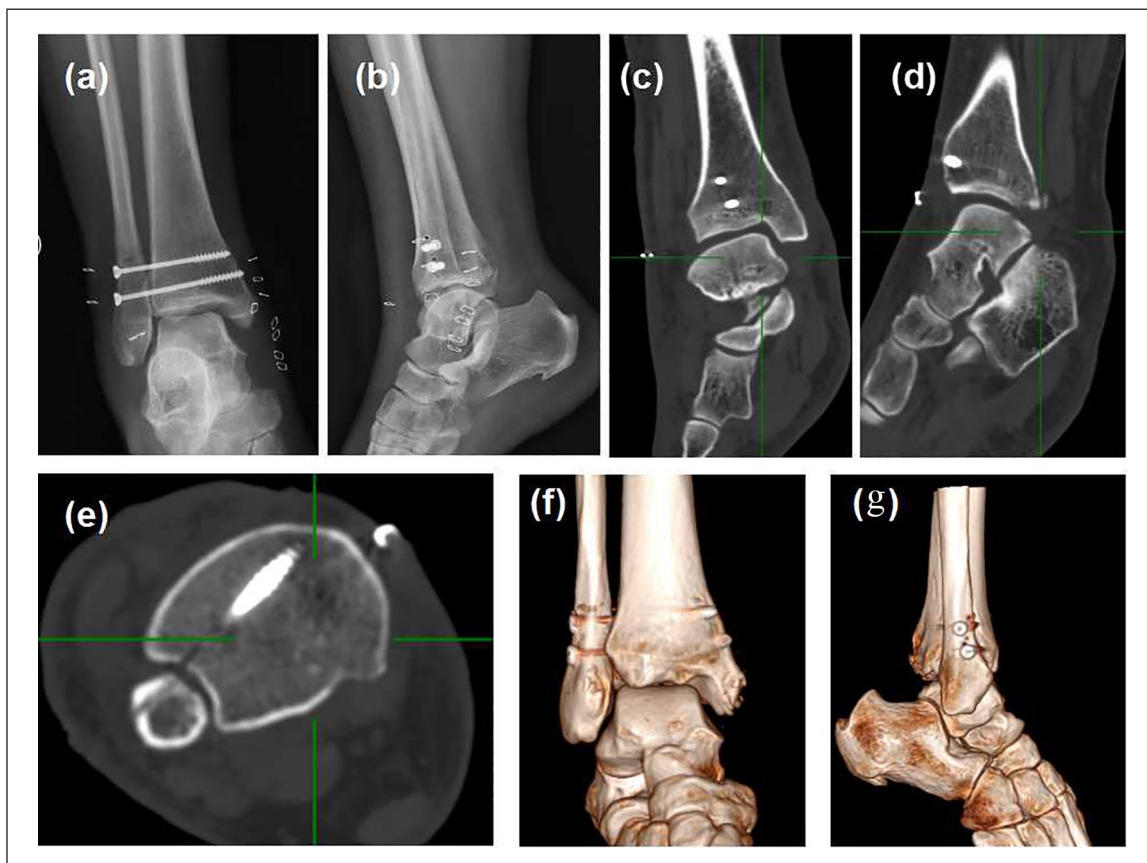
Postoperative images showing the satisfactory position of the injured ankle. (a, b) Postoperative radiographs showing full reduction of the distal dislocated fibula and near anatomical joint space of the ankle. (c, d) Satisfactory tibiotalar joint space on both coronal and sagittal views of CT scan. (e) Full reduction of the syndesmosis on an axial view of CT scan. (f, g) Postoperative 3D reconstructions of CT showing the syndesmosis fixation with two quadricortical lag screws and the nearly normal ankle joint position.
